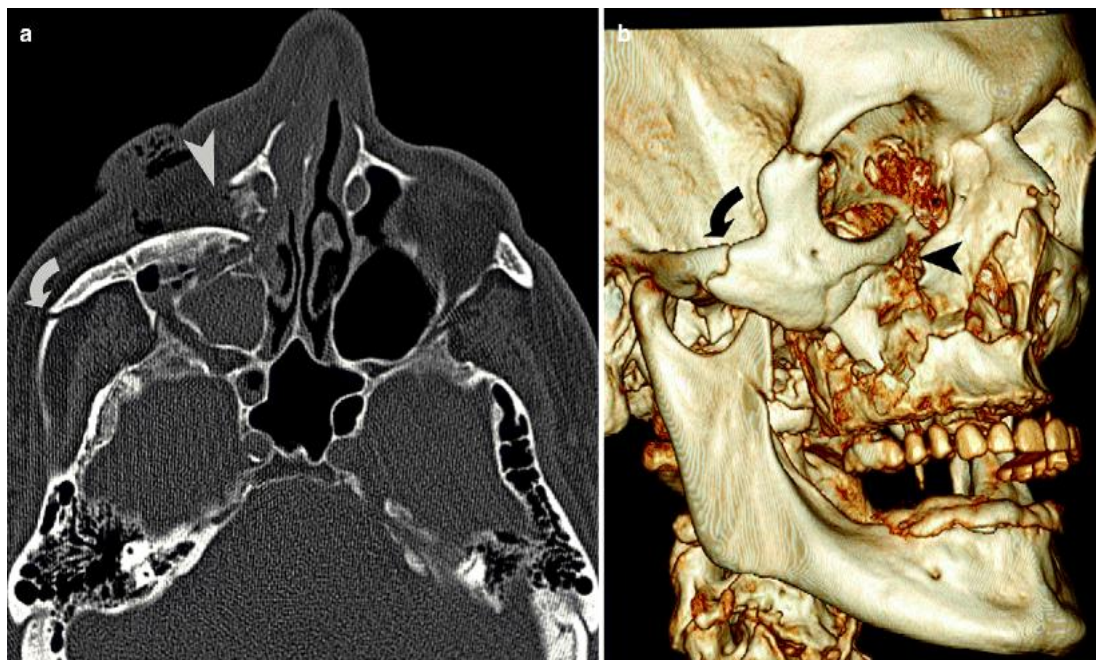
1 (a) Axial computed tomography images showing fracture of the anterior wall of right maxillary sinus and fracture of right zygomatic arch. (b) Three-dimensional rendered images showing better appreciation of the displaced fracture fragment of the anterior wall of right maxillary sinus
